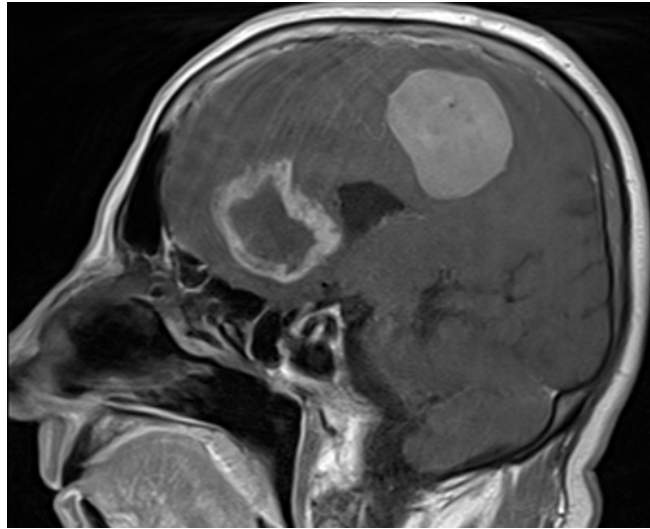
On brain MRI, two different mass lesions are detected; one in the frontal lobe and the other one in the parietal lobe.
